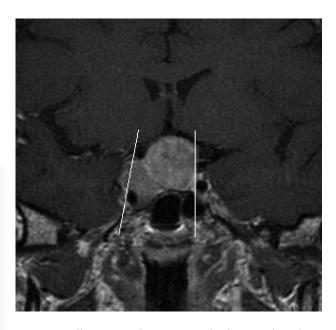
Sellar MRI T1 C. As an example, the MRI plane shows sections through the CS and both intracavernous and intracranial carotid artery segments. Knosp grading: right side 3, left side 0 Rycina 1. Rezonans magnetyczny siodła tureckiego (T1). Na przykładzie uwidoczniono przekrój przez zatoki jamiste oraz śródjamisty i śródczaszkowy odcinek tętnic szyjnych wspólnych. Zaawansowanie wg skali Knospa: strona prawa — stopień 3, strona lewa — stopień 0
